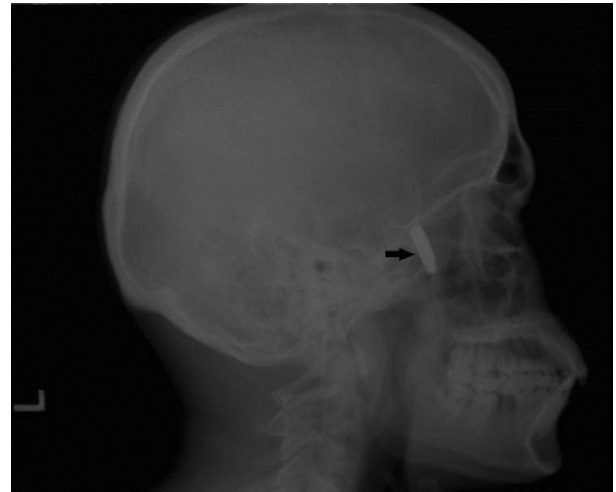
Lateral view radiograph demonstrating an AK-47 projectile round lodged in the ethmoid sinus.
